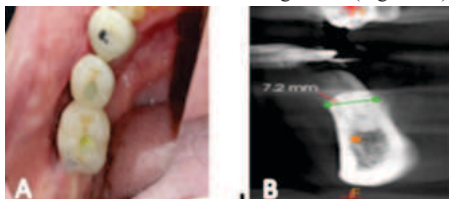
A- Prosthesis delivered, B- Postoperative CBCT
